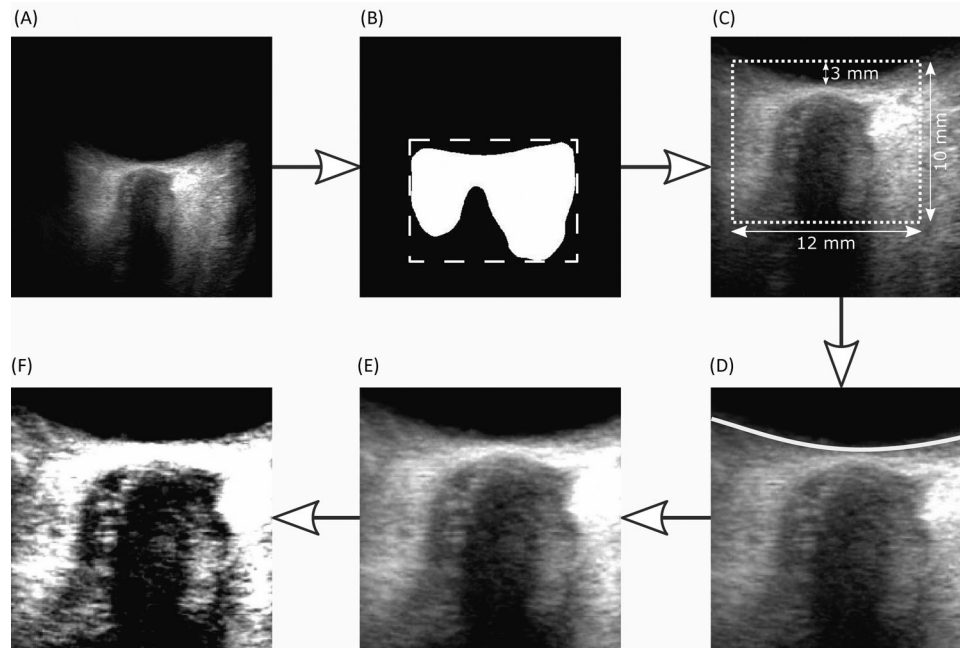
Region of interest selection and image enhancement. (A) Original B-mode ultrasound image. (B) Detection of the outline of the retrobulbar structures used for the initial image crop. (C) Detection of the optic nerve midpoint, that is, crossing of the nerve midline and the retina (white arrow). Next the image is cropped using a width of 12 mm and a depth of 10 mm around the nerve midpoint. (D) Retina detection and fitting of a second-order polynomial (white line). (E) Bandpass filtering of the cropped image. (F) Image enhancement of the bandpass filtered image
